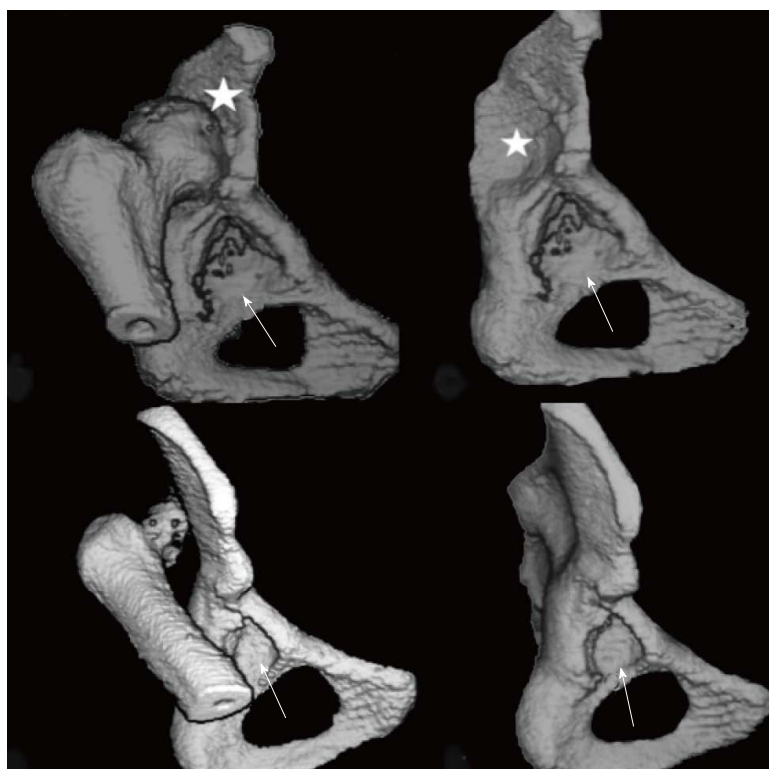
Three dimensional-computed tomography scans of the two subtypes of high dislocation. Arrows indicate the true and asterisks the false acetabulum.
